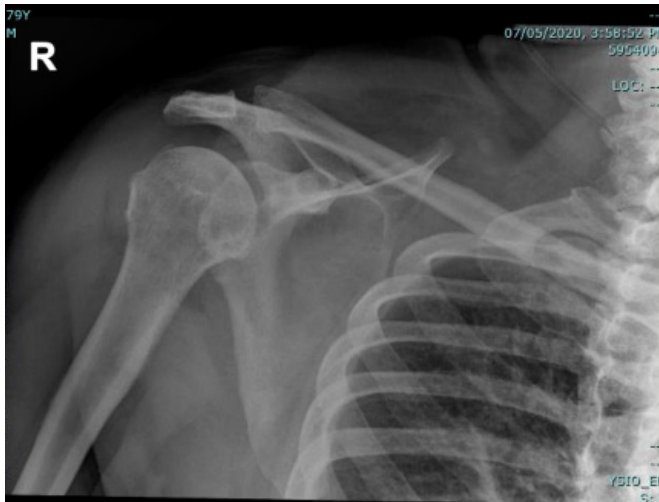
Anteroposterior-X-ray of right shoulder with a radiological interpretation of mild acromioclavicular and glenohumeral arthrosis, and rotator cuff calcific tendinitis without fracture or dislocation.
